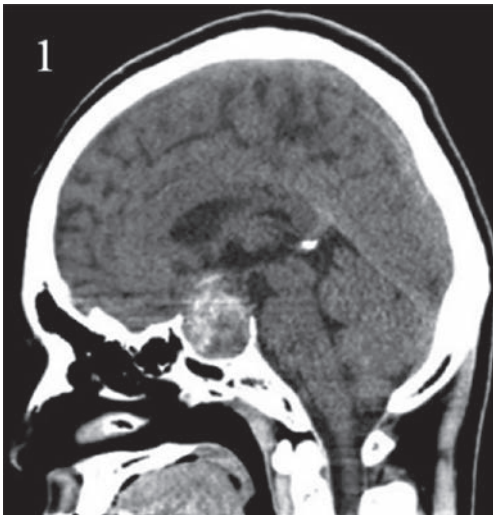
Preoperative brain CT revealed a 4-cm-diameter intrasellar and suprasellar high-density mass. This high-density area was suspected of bleeding.
